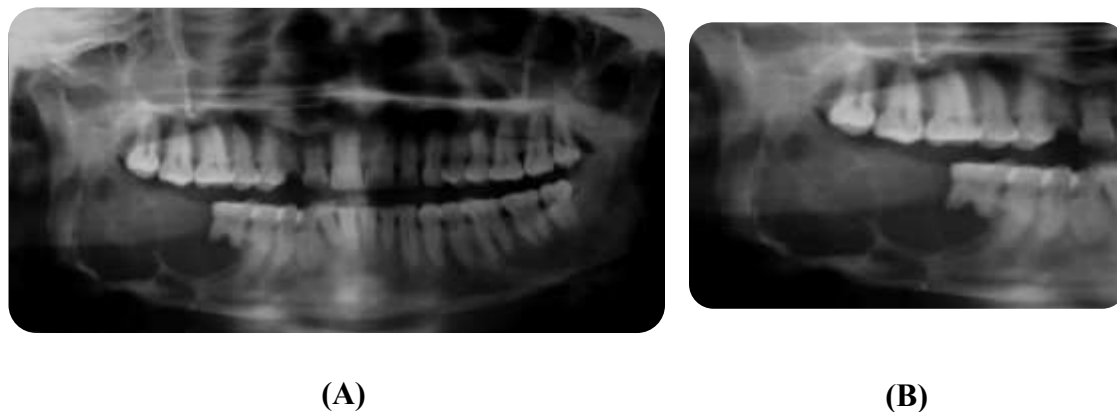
Orthopantomogram incidence showing multilocular radiolucent lesions in the right posterior mandibular region, extended to the right ramus.
